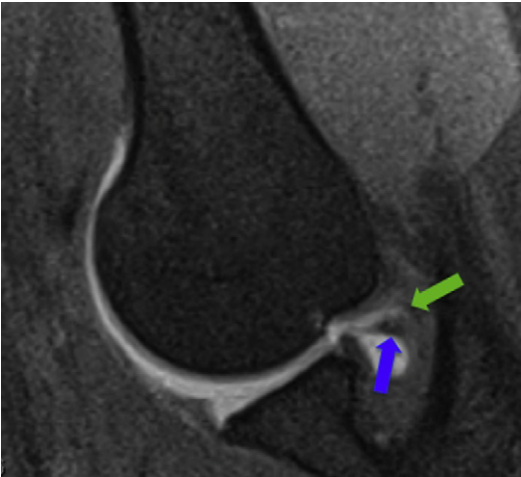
Rotary cuff cable and articular surface supra-spinatus tendon tear. ABER fat-suppressed T1-weighted image demonstrates the rotator cable (*blue arrow*) along the undersurface of torn, retracted supraspinatus tendon articular surface fibers (*green arrow*).
